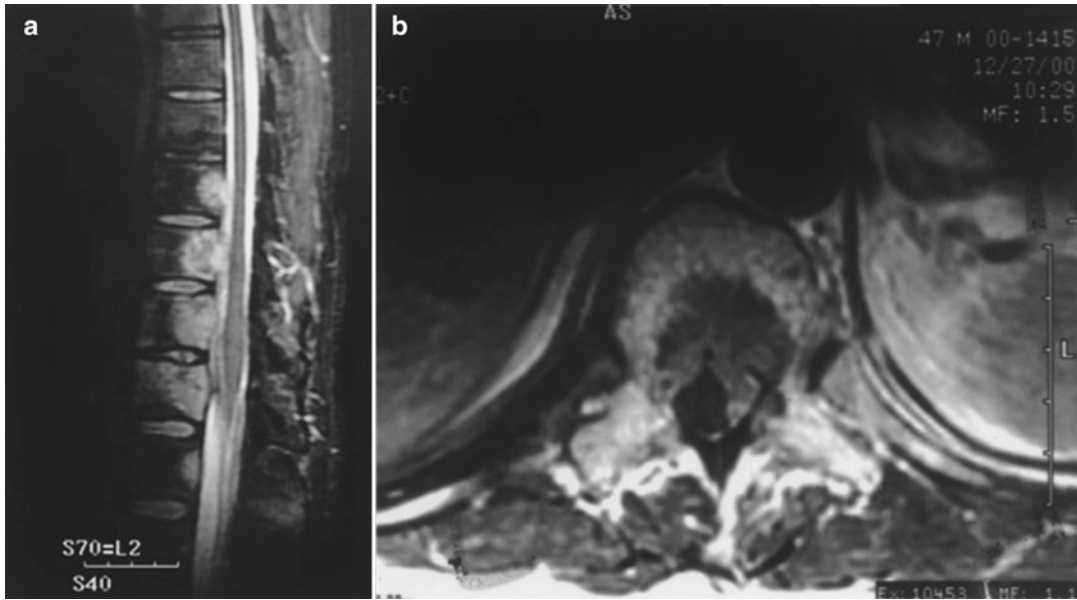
Sagittal (a) and axial (b) T2-weighted MRI images show multiple spine metastases. There is spinal cord compression at T12
